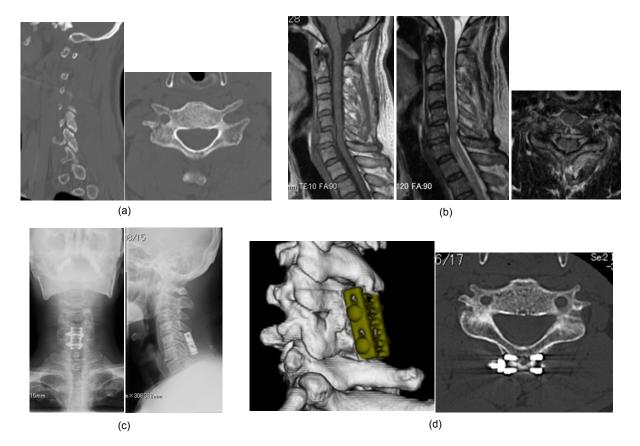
CT scans, magnetic resonance images, and plain X-ray images of Case 2
